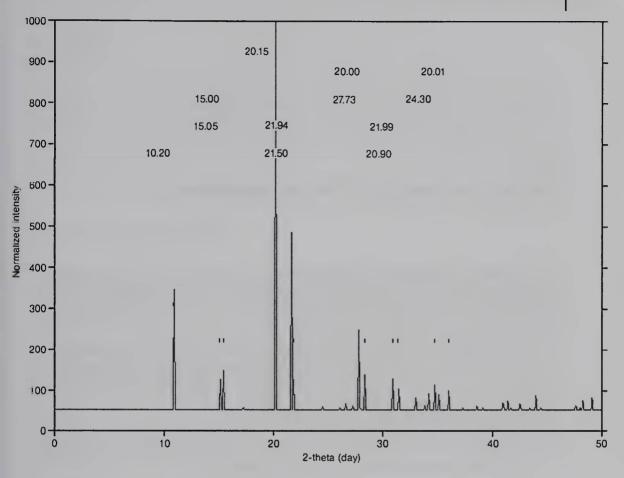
Calculated powder X-Ray pattern of SiPh₄.
